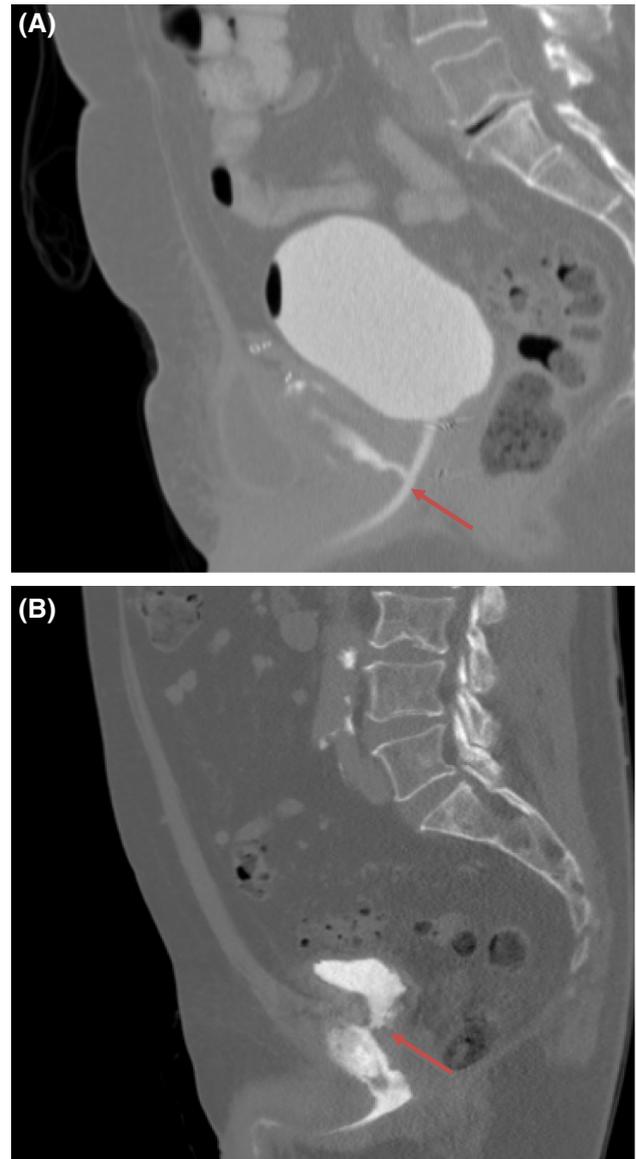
Sagittal views of a pelvic computed tomography scan demonstrating contrast extravasation (*arrow*) from prostatic urethra toward pubic bone (a) and involving the pubic symphysis (b) (*arrow*)
